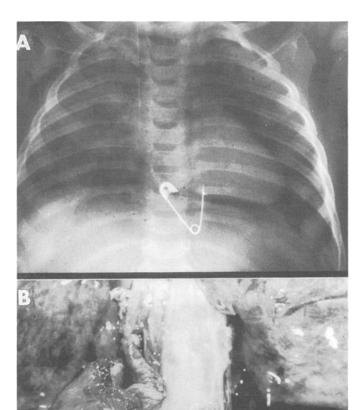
A chest X-ray (A) demonstrating the position of an open safety pin that had pierced the anterior wall of the esophagus (B) and posterior wall of the left ventricle causing cardiac tamponade.
